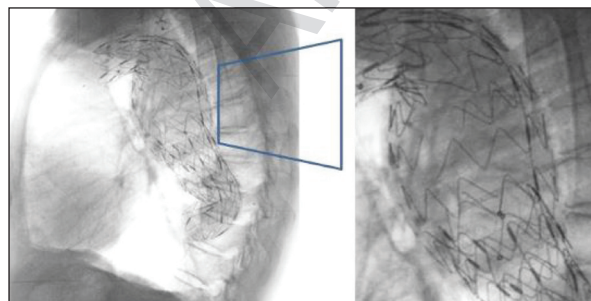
Lateral chest radiograph obtained 16 months after the initial TEVAR procedure, demonstrating fusiform dilatation of the proximal graft and separations and fractures in the metal components.
